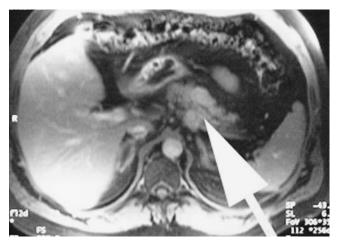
Magnetic resonance image from a patient with a multiple endocrine neoplasia type I pancreatic tumor (*arrow*). This was a nonfunctional tumor in the body of the pancreas.
